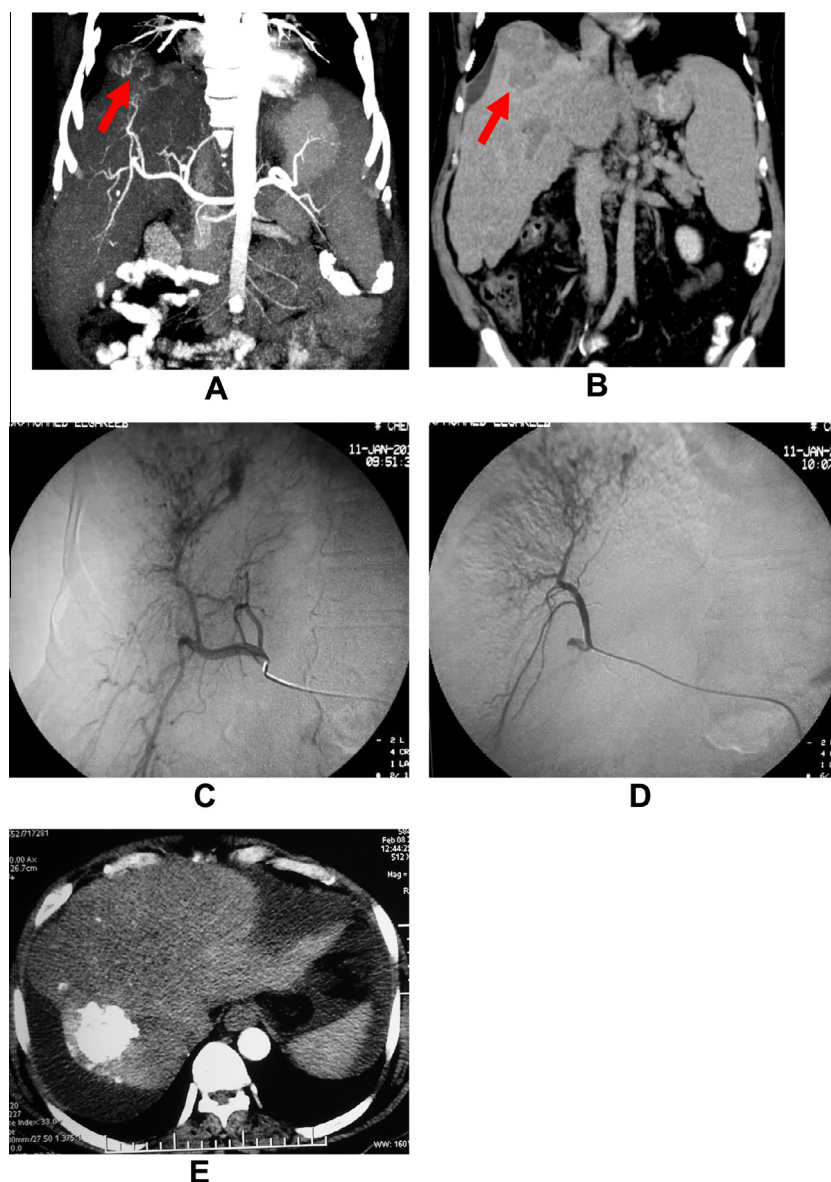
Peripheral mild fistula: 47 year old male patient with liver cirrhosis and right hepatic lobe HCC. (A) MIP hepatic arteriogram showing small arterio-portal fistula near the dome of the right lobe (arrow). (B) Coronal reformat at the porto-venous phase clearly demarcates the HCC due to rapid wash out of the contrast (arrow). (C) DSA of the right hepatic artery confirms the presence of the fistula and shunting of contrast to the small peripheral portal vein. (D) Selective catheterization and embolization of the fistula using gel foam particles followed with injection of cytotoxic drug/lipiodol mixture (E). Post chemoembolization of CT scan. The lipiodol is well concentrated within the lesion.
